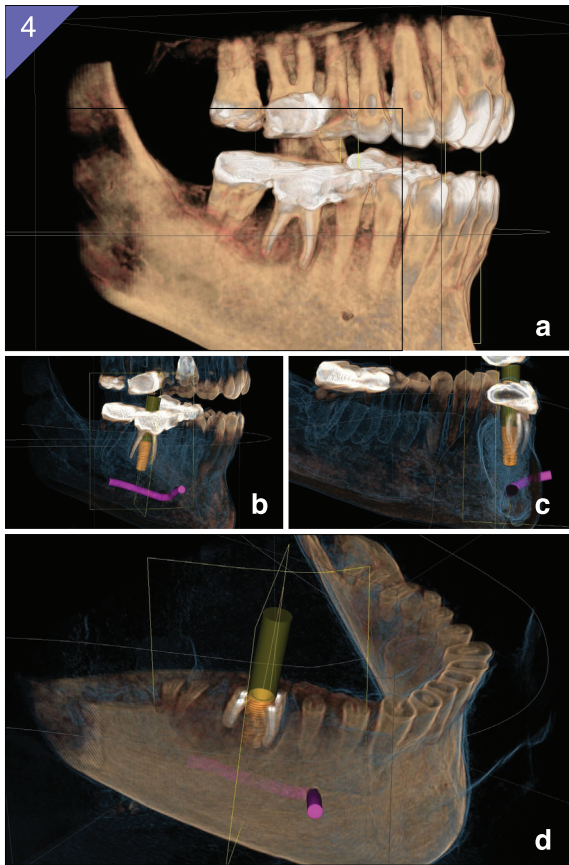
Implant planning using 3D rendering of CBCT scan. The planning software allows for virtual placement of the implant for viewing in relation to anatomical structures.
